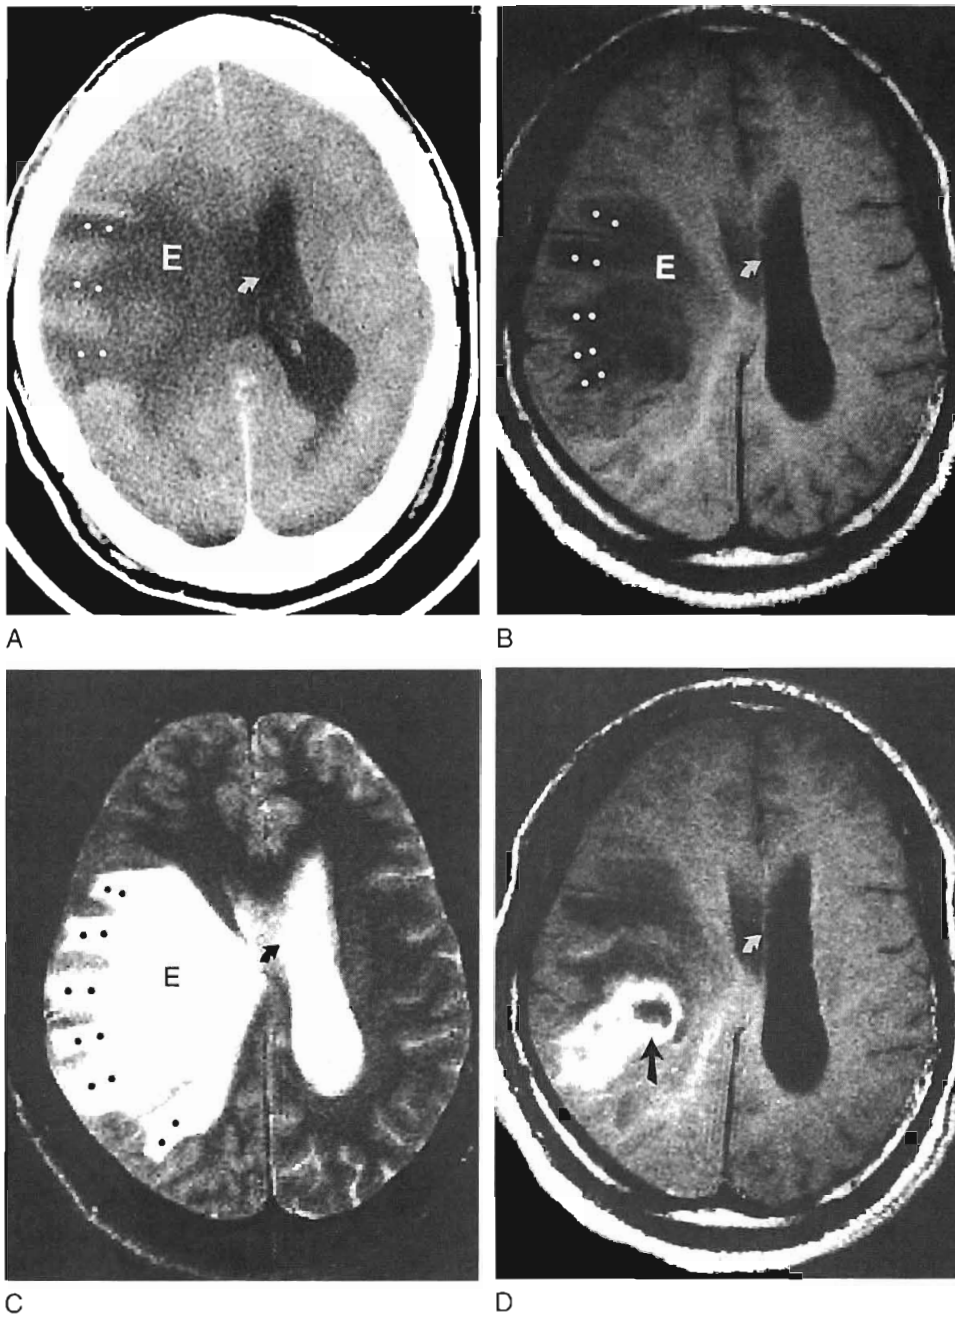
Vasogenic edema in glioblastoma. Non-contrast-enhanced axial CT scan (A), axial T1-weighted MRI scan (B), and axial T2-weighted MRI scan (C) all demonstrate an area of edema (E). The edema extends along the white matter fibers (dots), with normal gray matter interposed. Axial T1-weighted MRI scan following contrast enhancement (D) demonstrates the enhancing tumor nidus (arrow), distinct from the surrounding edema. Subfalcine herniation is also demonstrated on these images by displacement of the falx (curved arrows).
